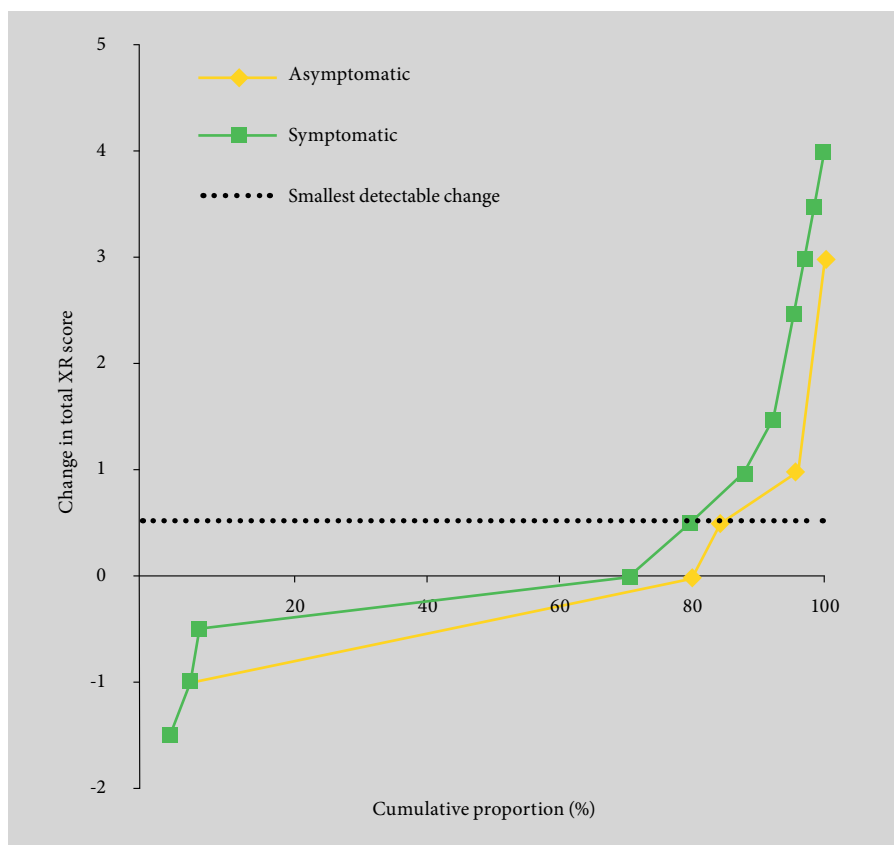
Cumulative probability distribution of the percentages of symptomatic and asymptomatic patients with a given change in total radiographic X-ray score. XR, X-ray radiography. Reproduced from Brown et al [33]©Wiley.
